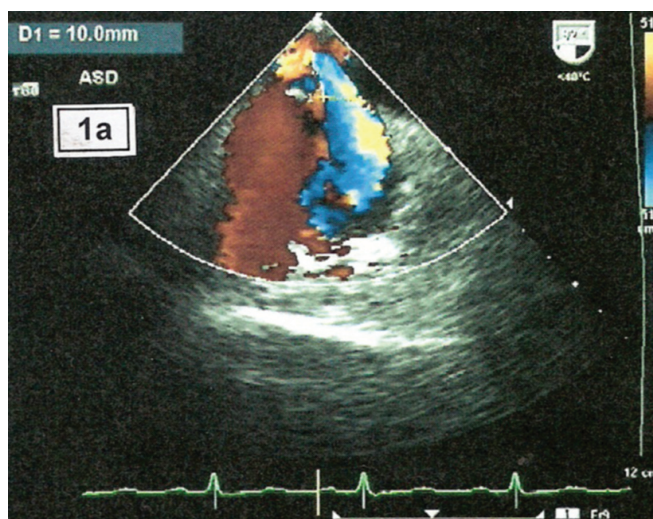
Transesophageal echocardiographic bicaval view showing secundum ASD.
